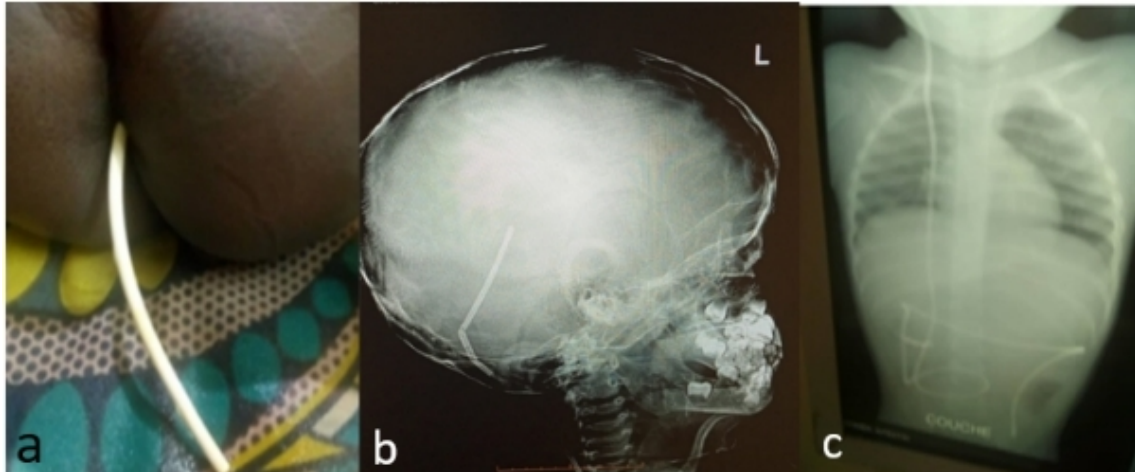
A four-week-old pretermed malnourished child with (a) Trans-anal protrusion, an X-ray of (b) an adequately placed ventricular catheter, and (c) ileocecal perforation and trans-intestinal migration of shunt hardware
